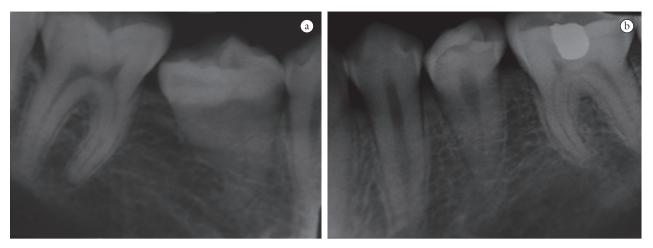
Periapical radiographs showing tooth 4.5 (a) and 3.5 (b). Note the crown with an irregular shape and size of tooth 4.5 (a) if is compared with tooth 3.5 with a normal size and shape but with a reduced root length (b).
